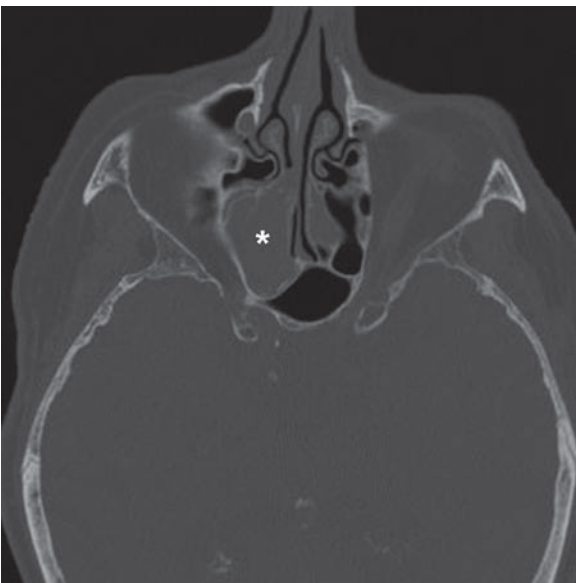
Mucocele. Axial CT shows an enlarged, opacified posterior ethmoid air cell (*asterisk*) with rounded convex borders. The surrounding sinuses are compressed
